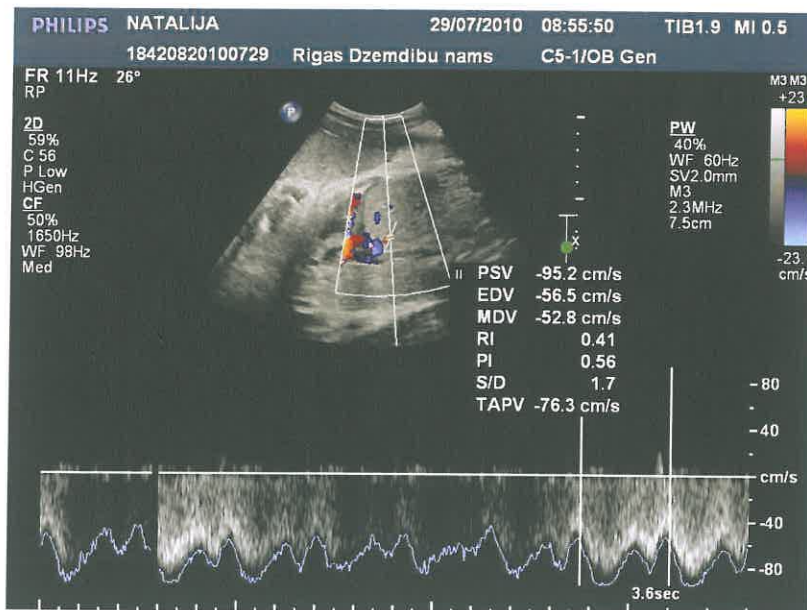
Figure N 12. Colour Doppler image of the fetal circle of Willis (gestational age 30 weeks).
